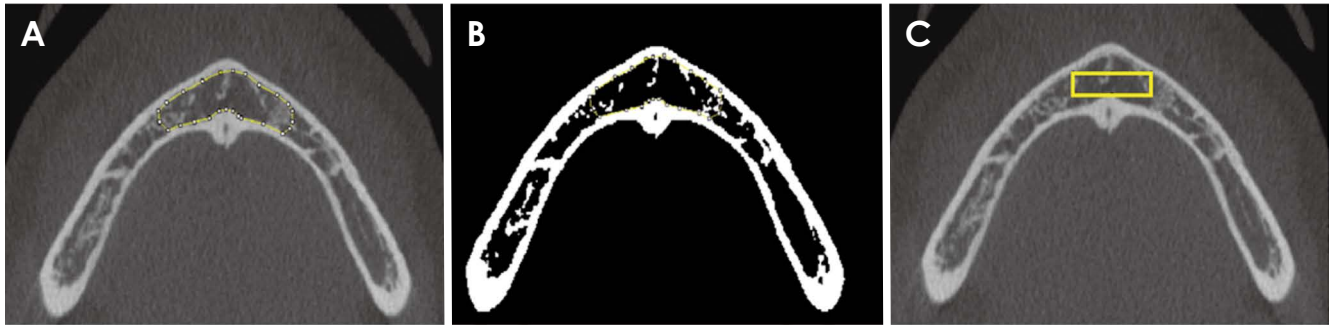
A. Axial section of cone-beam computed tomography (CBCT) with a region of interest (ROI) for assessing the bone volume fraction (BV/TV) in the trabecular bone. B. Binary image to assess the BV/TV. C. Axial section of CBCT with an ROI for evaluating the trabecular bone texture, such as the fractal dimension and lacunarity.
